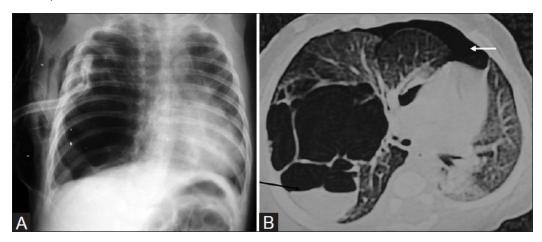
shows the appearance of pneumothorax in chest radiograph and the HRCT(Baum,G.l. and etal 1994).
